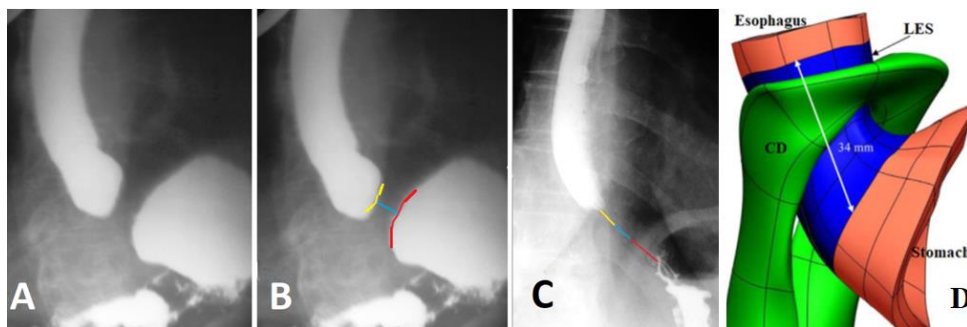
and scheme to it (B) of patient with GERD. Radiograph was done in a horizontal position with abdominal compression. The sharp shortening of the LES because of the opening of the supra-diaphragmatic part of the LES (yellow) and inside the abdominal part of the LES (red) was determined. Only the diaphragm part (blue) of the sphincter is closed. (Figure 3C) In an upright position during abdominal compression the LES contracted in response to the increased pressure in the stomach. It is visible as two longitudinal folds between the esophagus and stomach. Since the actual height of D-10 is ≈ 2 cm, the actual length of the LES is ≈ 3.4 cm. The LES parts: red - the abdominal segment, blue - inside the diaphragm, yellow - above the diaphragm. (Figure 3D) Three-dimensional model of the EGJ from the article by Yassi et al [18]. The length of the LES is 3.4 cm (blue). Its abdominal part is ≈ 2 cm. About 1 cm is located at the level of the crural diaphragm and 0.4 cm above the diaphragm.
